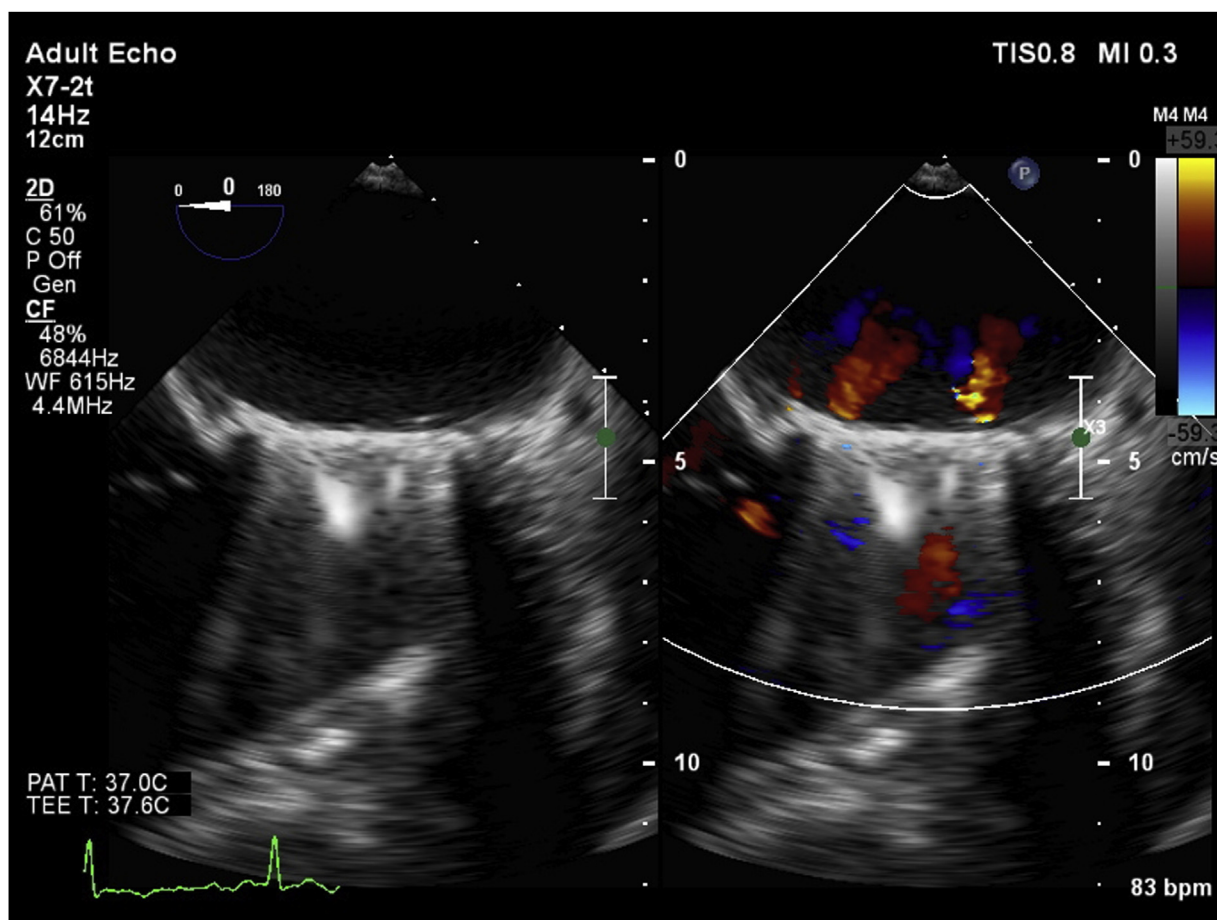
Transesophageal echocardiogram (TEE) before discharged showed good prosthetic mechanical MV position and functions.
